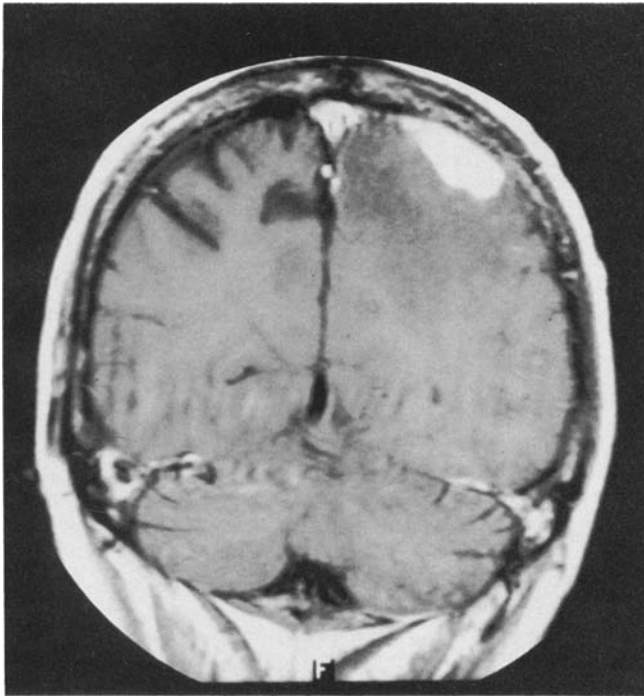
Magnetic resonance imaging scan with gadolinium showing a solid, enhancing mass (2 cm × 1.3 cm) in the left parietal area of a patient with AIDS and infection due to *Mycobacterium genavense*.
